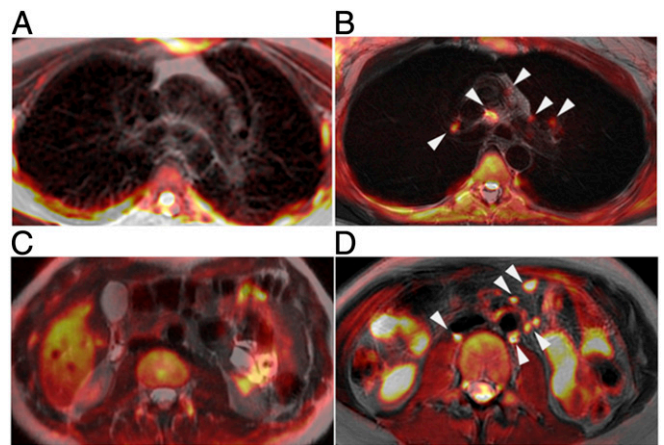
MRI shows that transplanted SCID patients have few lymph nodes. Merged T2-weighted and DWI datasets. In a 25-y-old female patient (P7, *Left*), no lymph-node-like structures were visible in the thorax (A) or the abdomen (C). In a 31 y-old control (*Right*), several lymph node structures are visible in the hilar, mediastinal (B), intraperitoneal, and retroperitoneal areas (D) (arrowheads).
